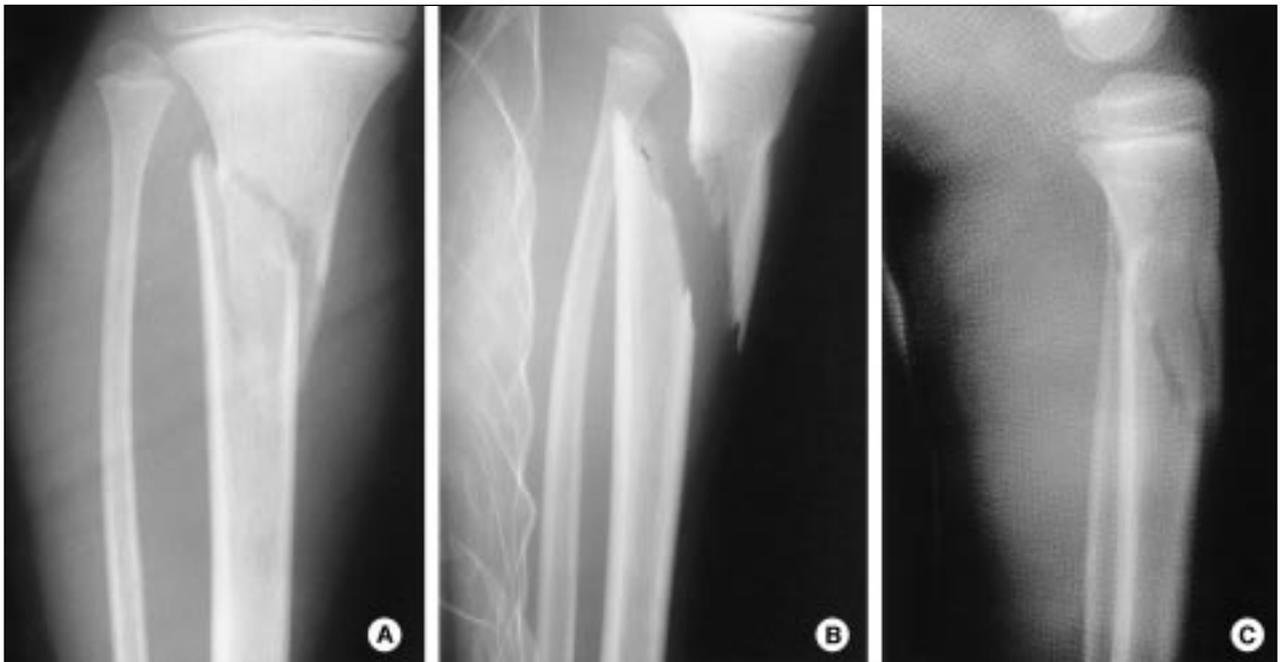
Fracture of proximal tibia and plastic deformity of fibula in a 6-year-old girl. A) Anteroposterior radiograph, B) Lateral radiograph. C) The tibial fracture was irreducible until the plastic deformity was corrected by using significant force under general anesthesia.
